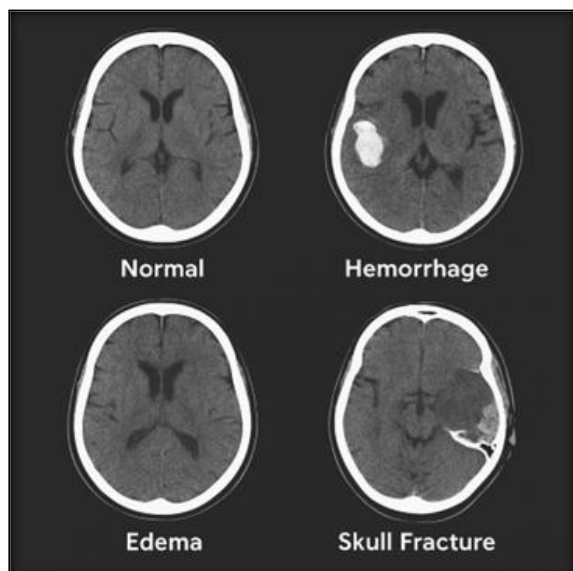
Diagnosis of different CT Findings
